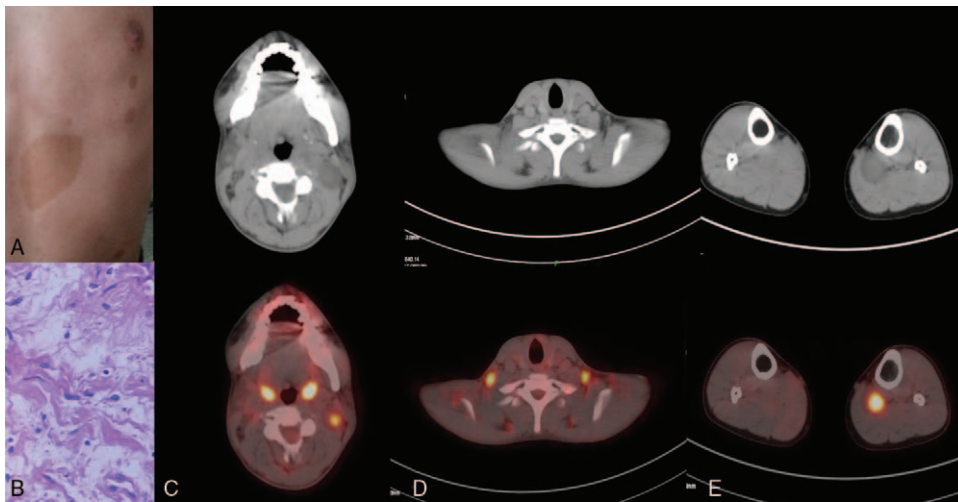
A–E. A 17-year-old man presented with several café-au-lait spots, the tissues of neck and left leg uptake of radiotracer were revealed by ^{18}F -FDG PET/CT scanning. Many café-au-lait macules were widely distributed in anterior and posterior chest wall of this patient, which is $>15\text{ mm}$ of diameter (A). These (C, E) were confirmed as benign neurofibroma by pathology (B). The hypermetabolic lesions under sternocleidomastoid, near piriformis, and gastrocnemius of left were neurogenic tumors. The hypermetabolic soft tissues of pharynx were physiological (C). The symmetric hypermetabolic tissues, which located in clavicular region, were BAT (D). BAT=brown adipose tissue, FDG=fluorine-18-fluorodeoxyglucose, PET=positron emission tomography.
